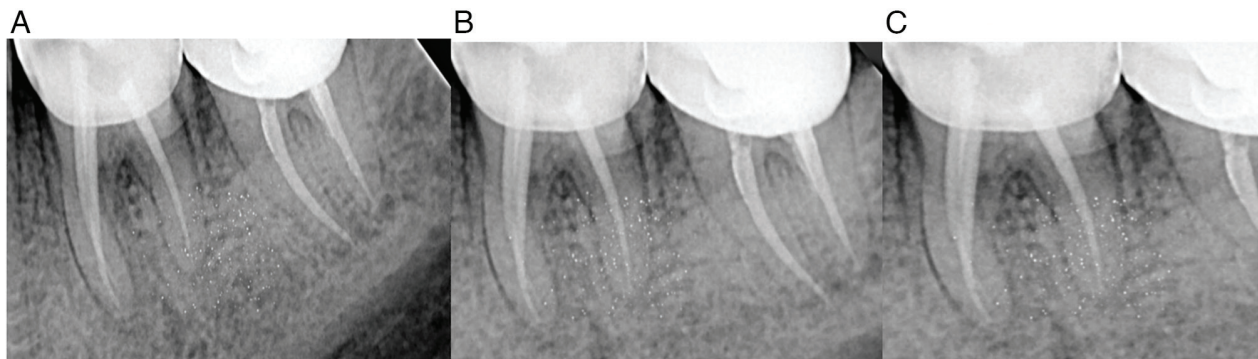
Radiographic follow up of tooth no. 36. (A) Follow-up IOPAR with respect to tooth no. 36 at 6 months. (B) Follow-up IOPAR with respect to tooth no. 36 at 12 months. (C) Follow-up IOPAR with respect to tooth no. 36 at 2 years. IOPAR, intraoral periapical radiograph.
